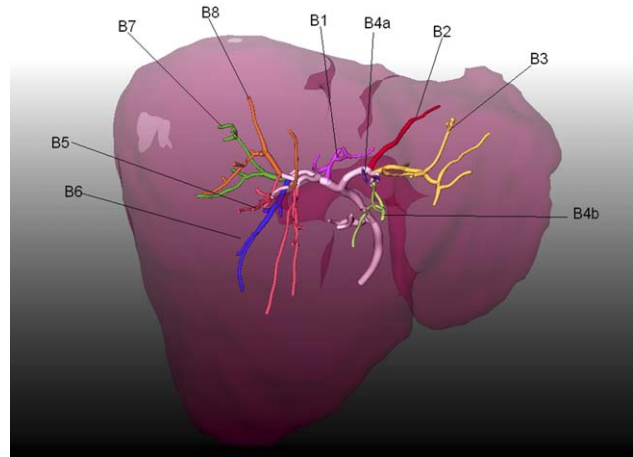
Three-dimensional CT cholangiogram in a liver model, biliary radicles are coded and numbered according to the respective Couinaud segment they drain.
